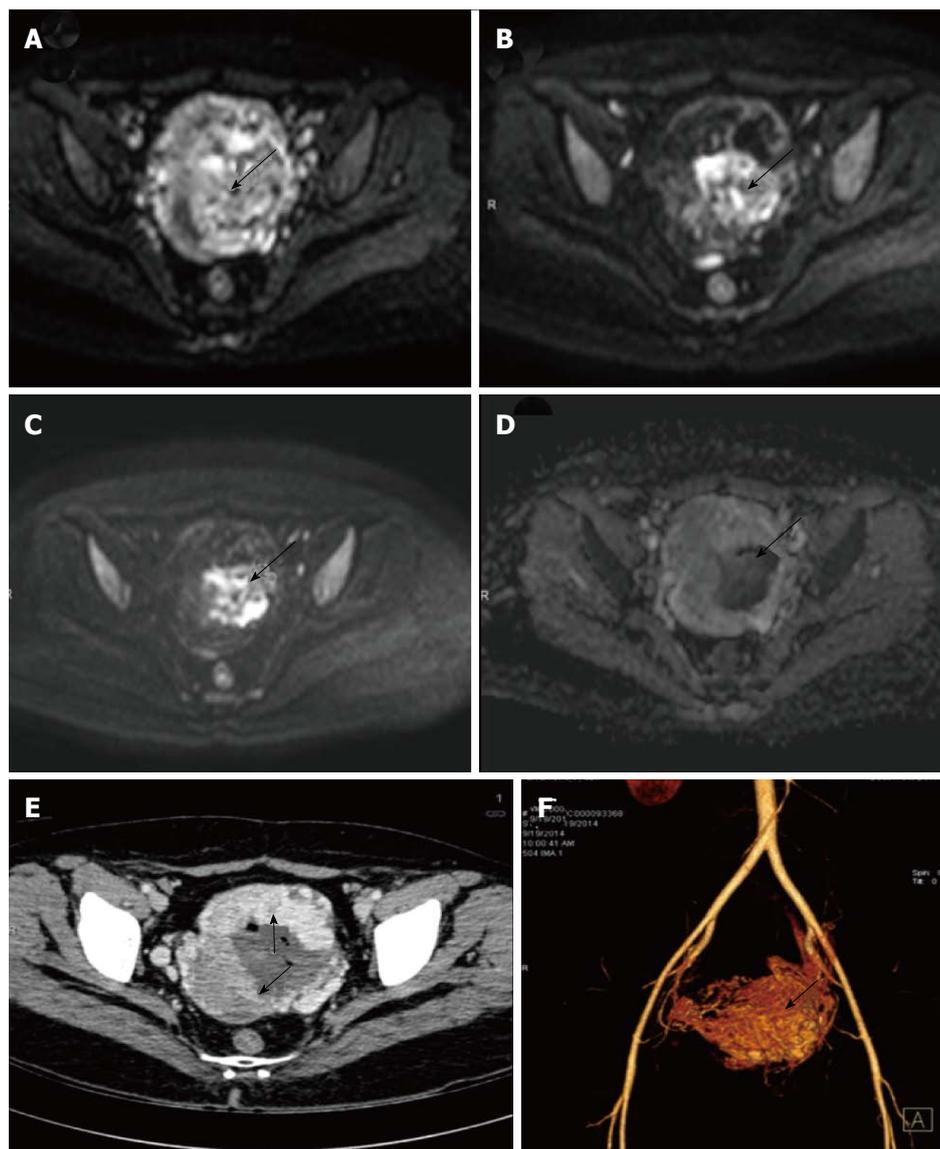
Gestational trophoblastic tumor. Axial diffusion weighted imaging b 0 (A), b 400 (B) and b 800 (C) and images of known case of gestational trophoblastic tumor shows significant restricted diffusion in the center of the mass (arrow). Note there is spurious restriction in ADC image (D). Axial contrast enhanced CT (E) showing the enhancing uterine mass (arrows) with nonenhancing central area likely hemorrhage which is responsible for the spurious diffusion restriction on DWI. CT angiography image (F) showing marked vascularity of the mass leading to intratumoral hemorrhage. ADC: Apparent diffusion coefficient; DWI: Diffusion weighted imaging; CT: Computed tomography.
